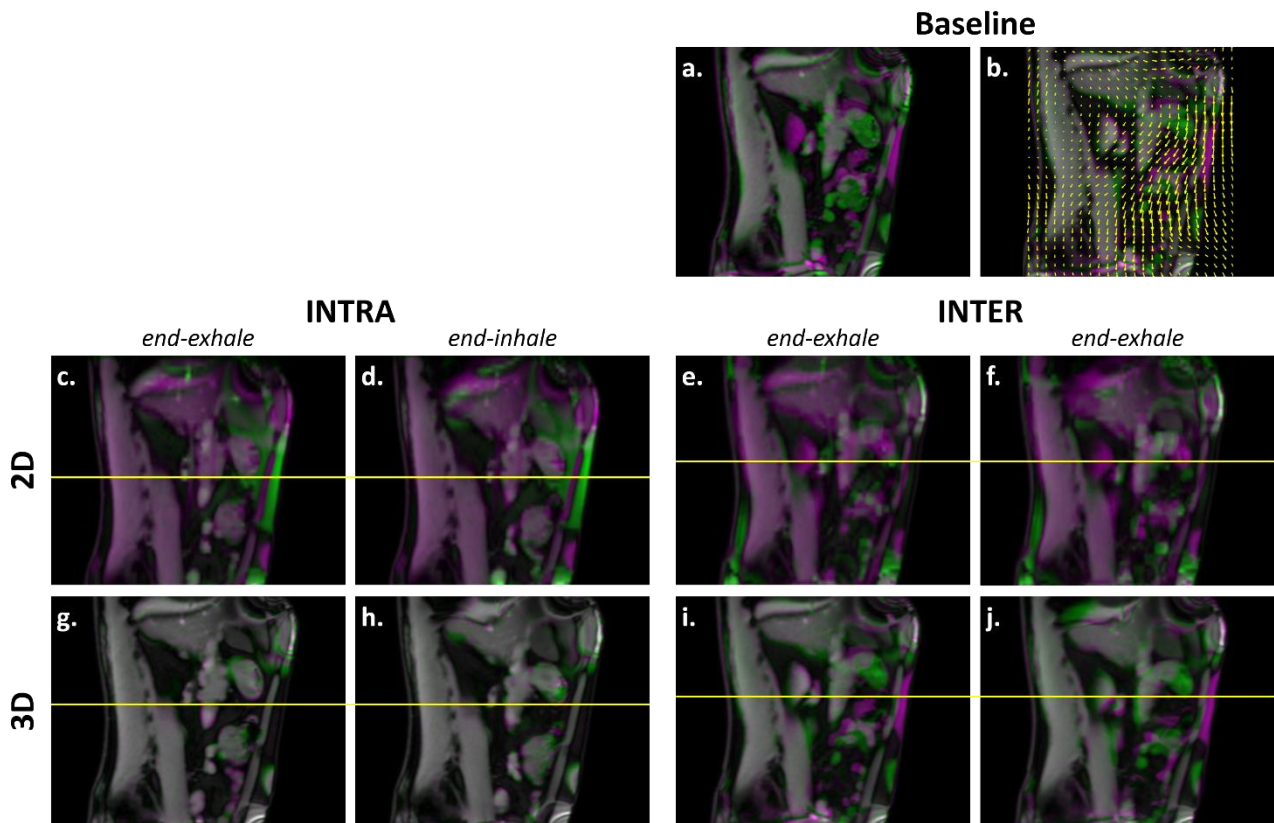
Qualitative results for P06. Baseline variations: (a.) overlay between the reference MRI and the end-exhale phase of 4DMRI R1 S2; (b.) baseline DIR output. Model estimation error: overlay between model output (violet) and GT slices (green), for the 2D intra S1 (c.-d.), 2D inter (e.-f.), 3D intra S1 (g.-h.), 3D inter R1 (i.-j.) scenarios. The yellow line highlights respiratory motion between the end-exhale (left) and end-inhale (right) respiratory phases in each scenario.
